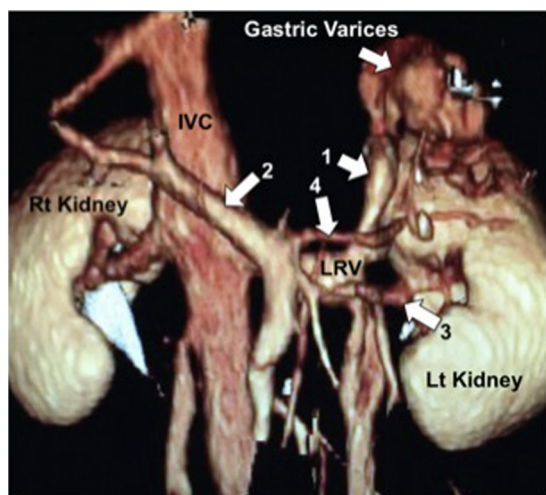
Volume-rendered image from a preprocedure CT showing a large gastric varix with a gastrorenal shunt (arrow 1) draining into the left renal vein (LRV). The portal vein (arrow 2), LRV (arrow 3), splenic vein (arrow 4), and inferior vena cava (IVC) are also indicated.
